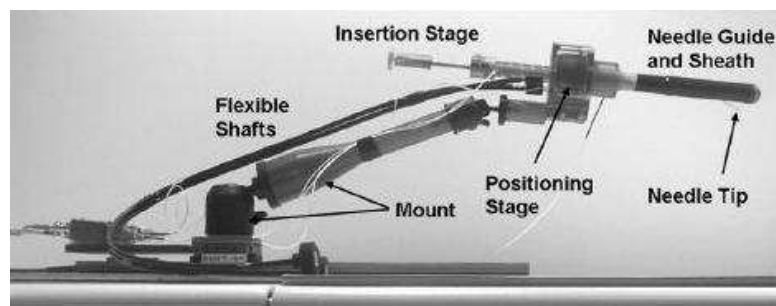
Side view of the MRI-compatible needle placement robot developed by Krieger *et al.*
